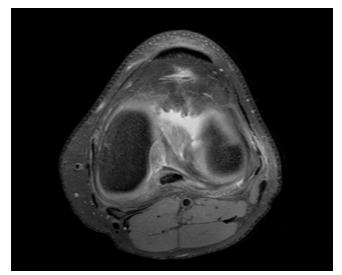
Axial magnetic resonance imaging of the patient's left knee shows medial and lateral menisci and the meniscomeniscal ligament.
